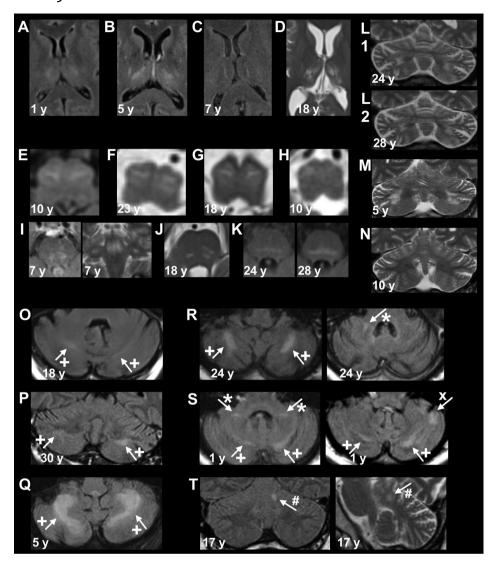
Infratentorial and thalamic MRI findings in POLG-related ataxia. Thalamic lesions in (A) P18; (B) P23; (C) P05; (D) P06. Brain stem inferior olivary lesions in (E) P12; (F) P01; (G) P06; (H) P04. Brain stem pontine lesions in (I) P05; (J) P06; (K) P19. Cerebellar atrophy in (L) P19 with mild progression within 4 years; (M) P23; (N) P12. O-T: Cerebellar lesions (+, bihemispheric deep white matter lesions; \*, medial cerebellar peduncle lesions; x, cerebellar gray-matter lesion; #, nodular white-matter lesion) in (O) P06; (P) P17; (Q) P23; (R) P19; (S) P18; (T) P10. Disease duration is indicated in the bottom left of each image.
